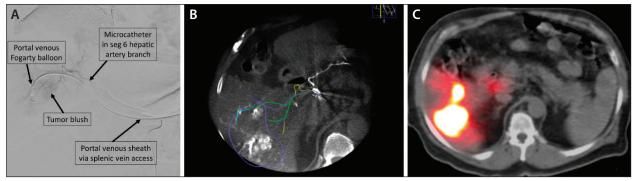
Angiogram with portal venous balloon inflated demonstrating redirection of arterial flow into the tumor and cessation of flow to the portal venous system (A). Intraprocedural pretreatment CBCT with portal venous balloon inflated to mitigate the APS, demonstrating perfusion of the tumor (B). Immediate posttreatment SPECT/CT with Y90 microsphere deposition into the intended treatment zone (C).
